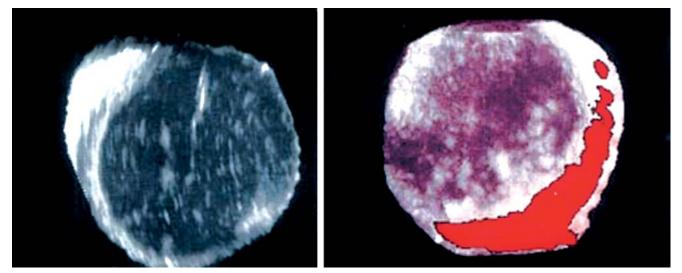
Three-dimensional scan of an ovarian cyst. Note regular walls of the cyst and echogenic content suggestive of a benign lesion. Corpus luteum cyst was found at the time of laparoscopy. Three-dimensional power Doppler scan of the same corpus luteum cyst. Single vessel arrangement is clearly displayed at the periphery of the cystic lesion
